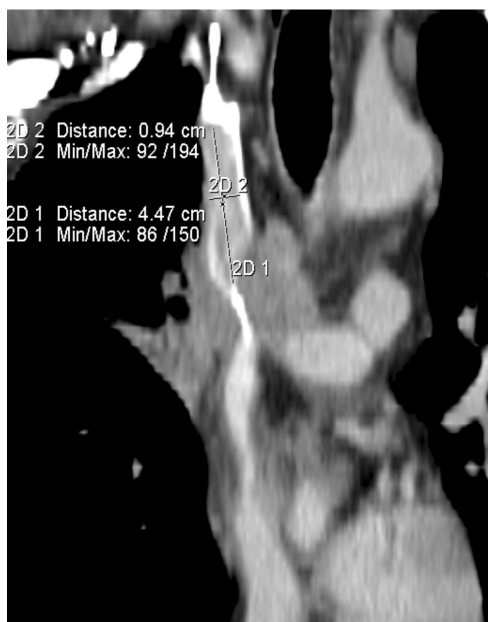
Pre-procedure CT – evaluation of the stenotic SVC segment enables procedure planning and choice of suitable equipment.
